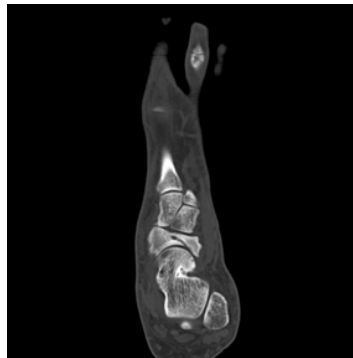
CT confirmed a fracture in the navicular bone.
